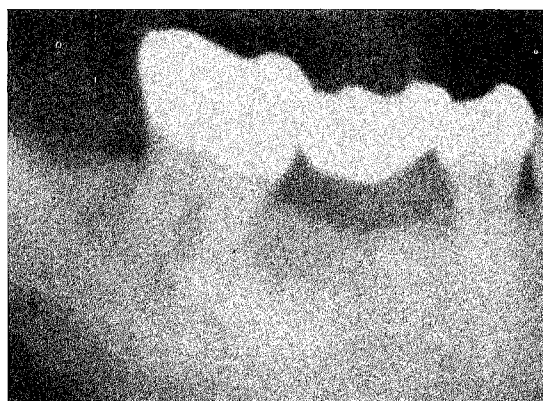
Radiograph showing a radiopacity in the area of the mandibular second premolar and first molar
